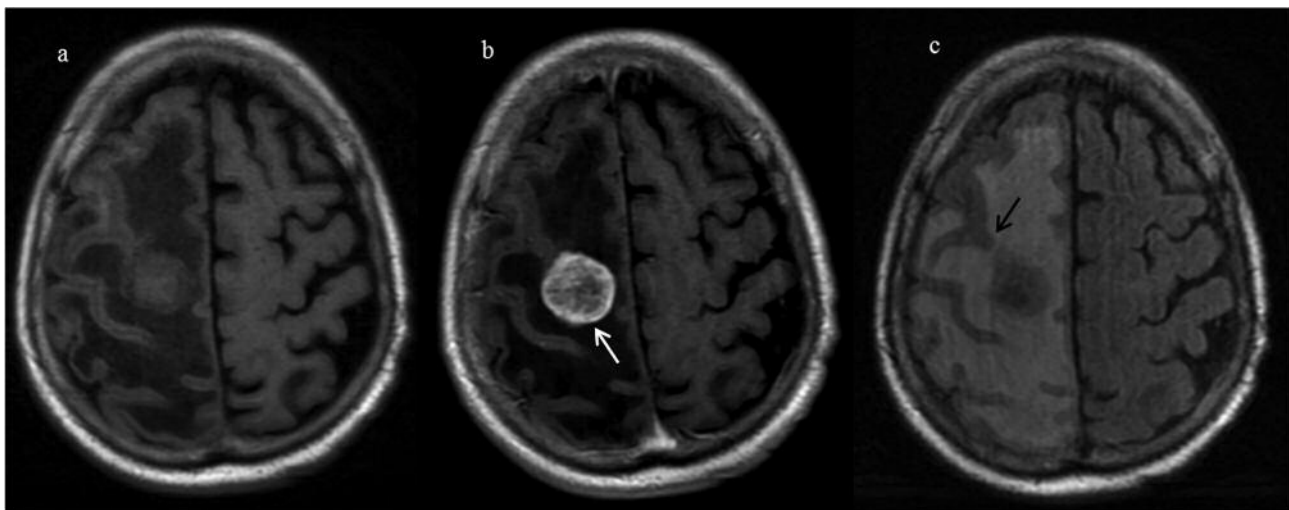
Cerebral metastasis from colon carcinoma. Axial FLAIR T1-weighted (a), contrast-enhanced FLAIR T1-weighted (b) and unenhanced FLAIR T2-weighted images (c). Note the peripheral rim sign (white arrow) on gadolinium-enhanced T1-weighted FLAIR image (b), i.e. a thin rim of more intense enhancement on the outer border of the enhancing lesion. Unenhanced FLAIR T2-weighted axial image (c) does not show signal alteration (black arrow) in the brain cortex adjacent to the area of contrast-enhancement (b).
